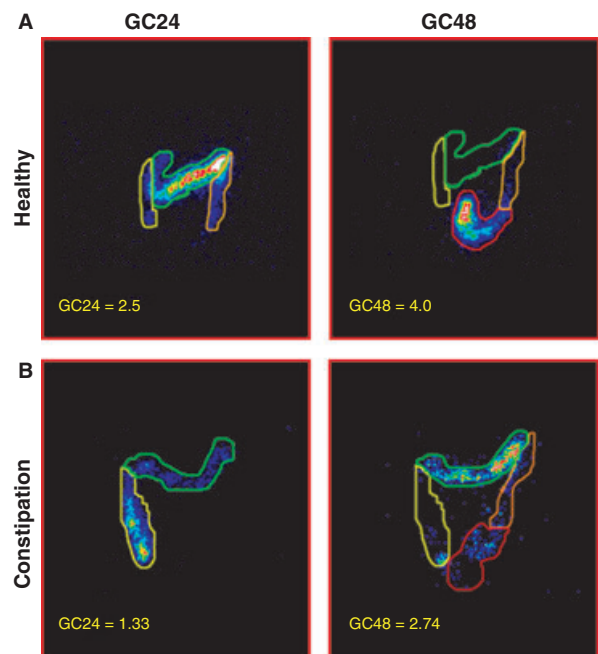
Colonic transit scintigraphy: This shows examples of colonic transit scintigraphic images (A) from a healthy subject with a normal geometric center (GC) count at 24 and 48 h and (B) from a subject with constipation showing abnormally low values for geometric center of a isotope meal at 24 and 48 h due to retention of radioisotope in the colon indicating delayed colonic transit.
